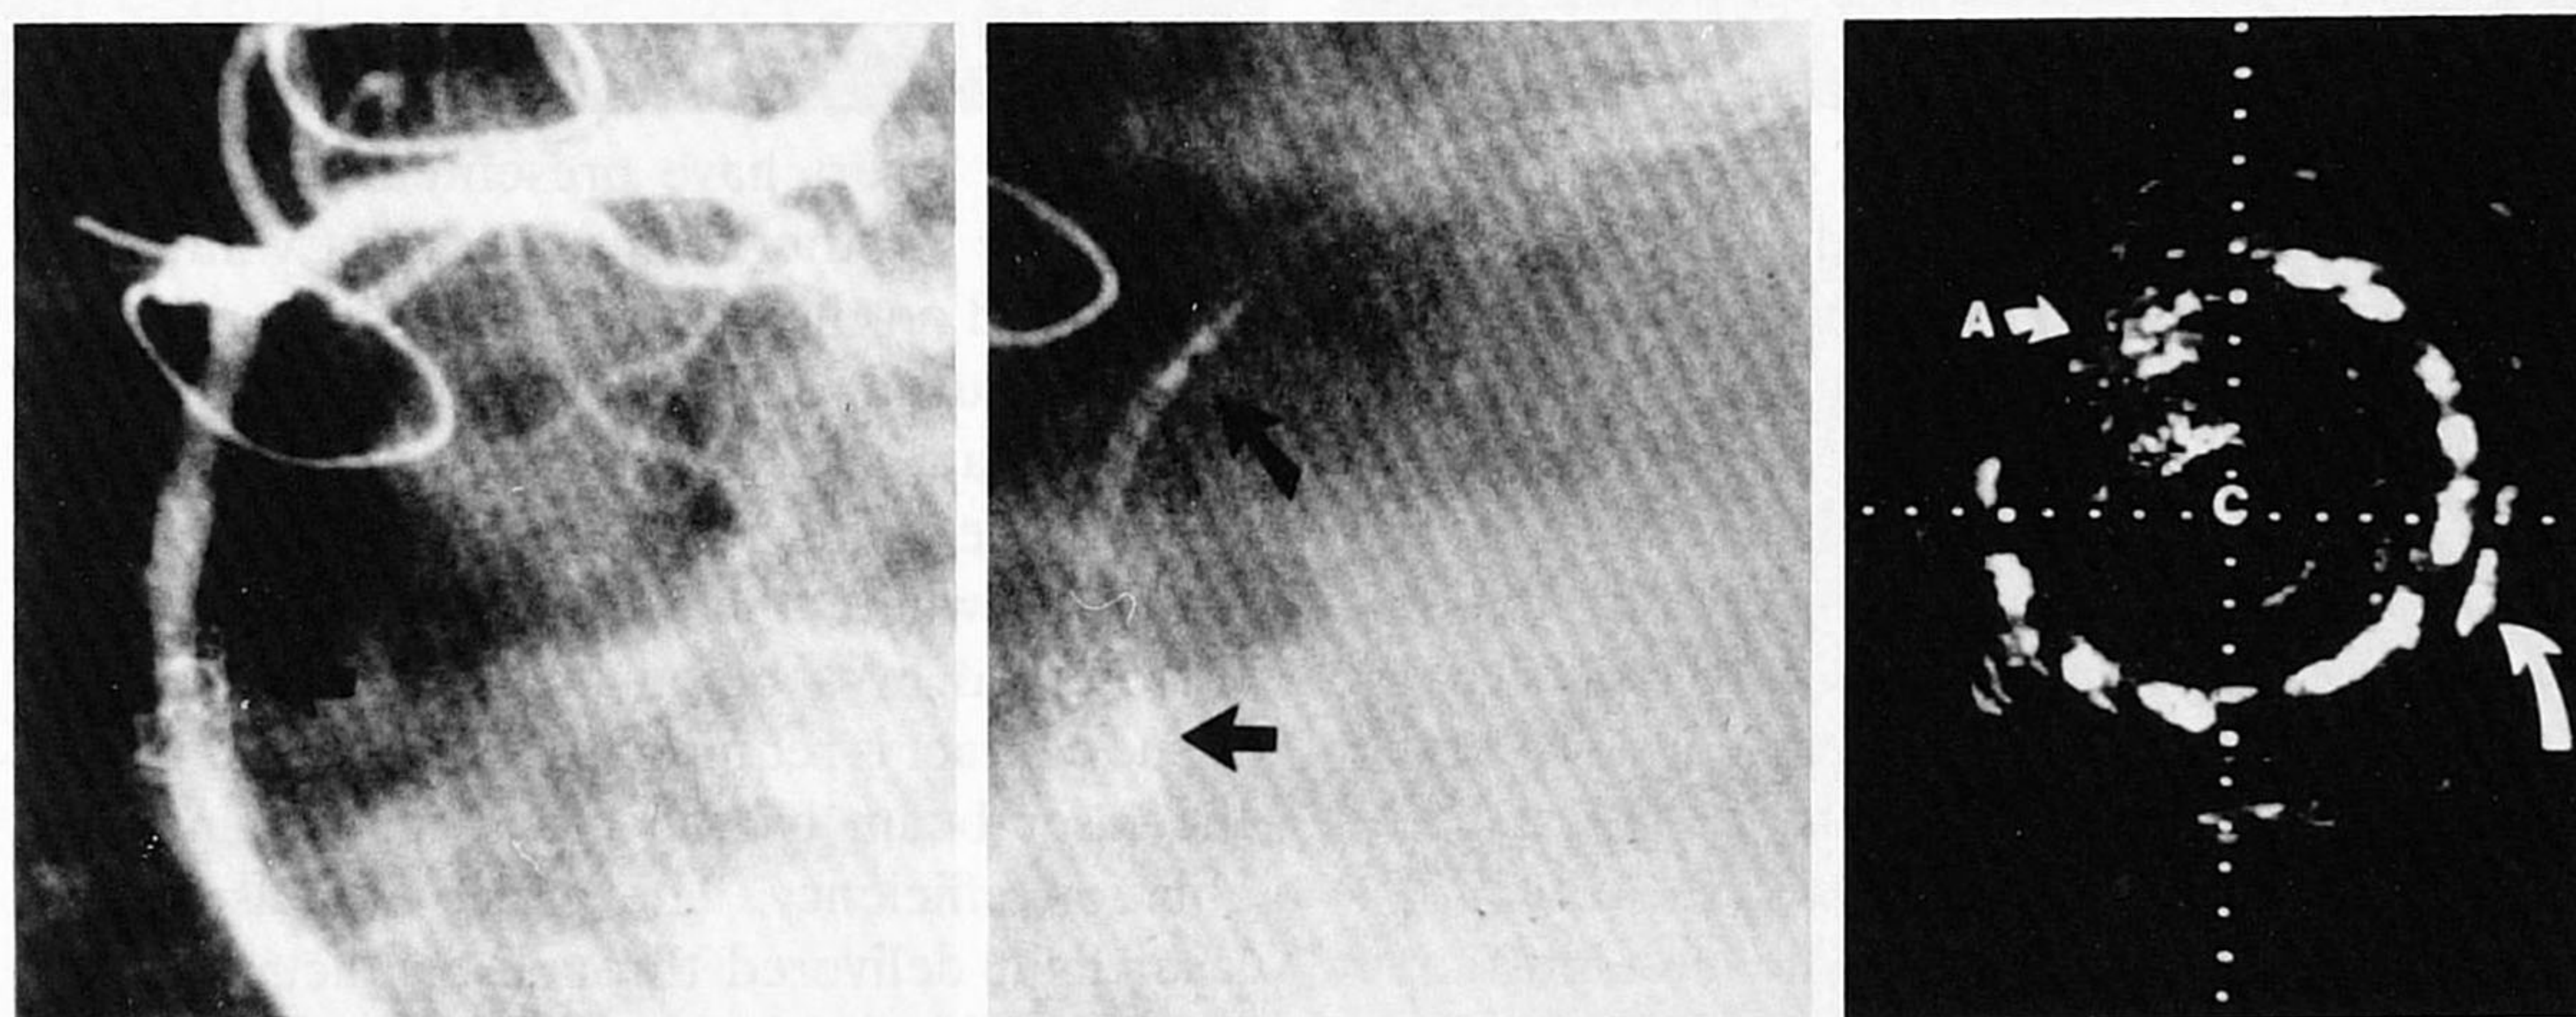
In vitro intravascular ultrasound examination of left anterior descending artery that was stented 24 hours earlier for a severe dissection during PTCA. (The patient died from intracerebral hemorrhage 12 hours after stenting.) The inner circle (c) is the actual intravascular probe itself. The outer echo-dense pattern is caused by the stent wires (large arrow). The lumen is the echo-free space inside the stent. The stent effectively tacked back the dissection and restored the circular configuration of the vessel. (Reprinted with permission.⁶¹)
